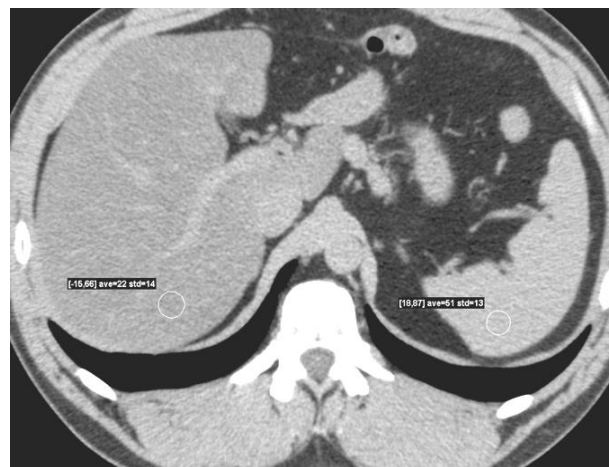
Fatty liver in a 40 year old man with dyslipidemia and elevated AST and ALT. CT shows diffusely decreased density compared to the spleen, with Hounsfield Units [HU] of 22 in the liver target area versus HU of 51 in the spleen target area.
